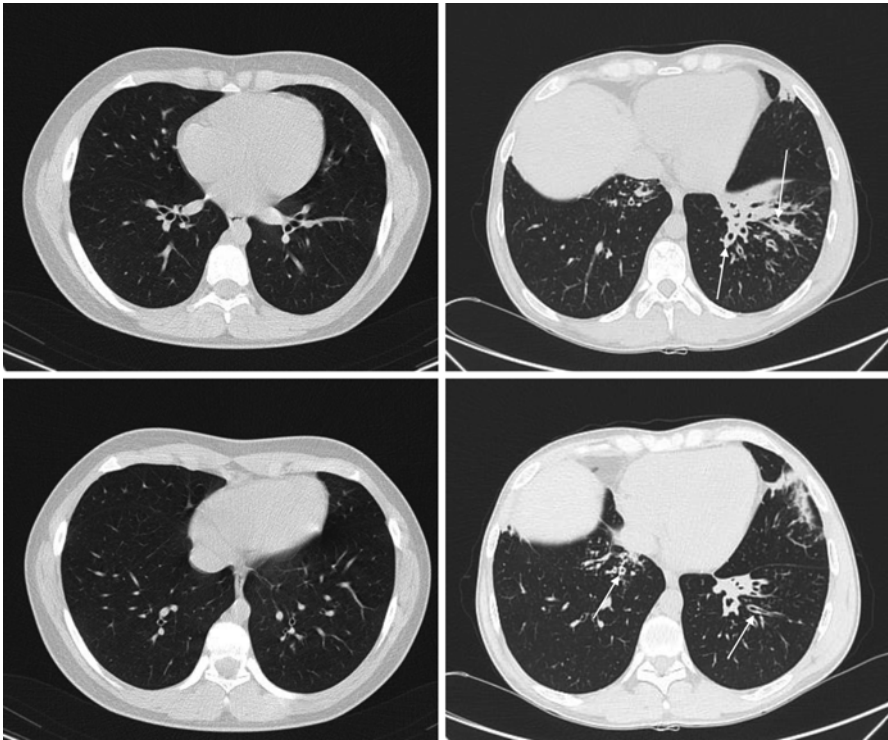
Lung CT scans from XLA patients. While some patients do not develop bronchiectasis (*left panels*), many XLA patients tend to develop bronchiectasis (*right panels, white arrows*) even when under regular immunoglobulin replacement treatment (Courtesy of Dr. MP Bondioni, Pediatric Radiology Unit, University of Brescia, Spedali Civili di Brescia, Italy)
